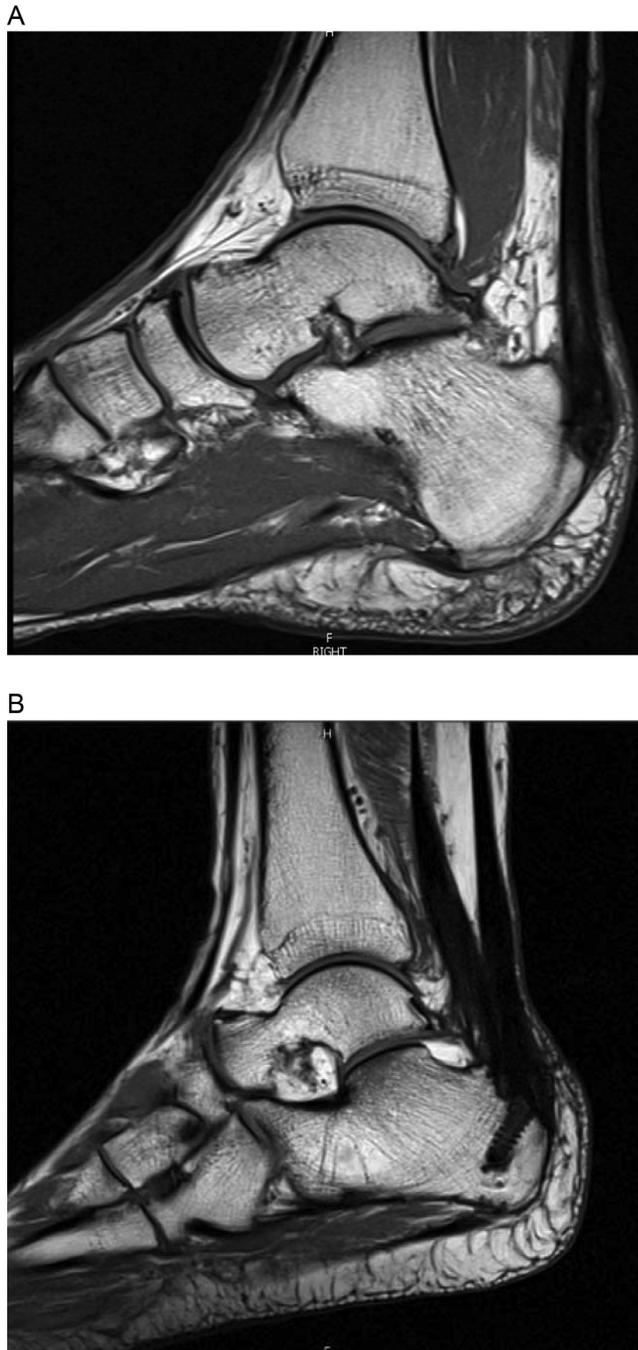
Preoperative (A) and postoperative (B) magnetic resonance imaging comparison of calcific insertional Achilles tendinopathy repair with flexor hallucis longus transfer and the Achilles Midsubstance SpeedBridge construct.
